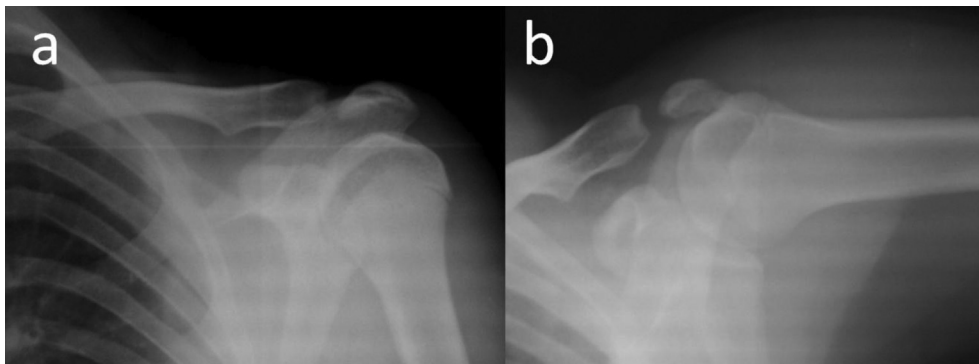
a: Anterio-Posterior x-ray of shoulder. b: Lateral x-ray of shoulder.
